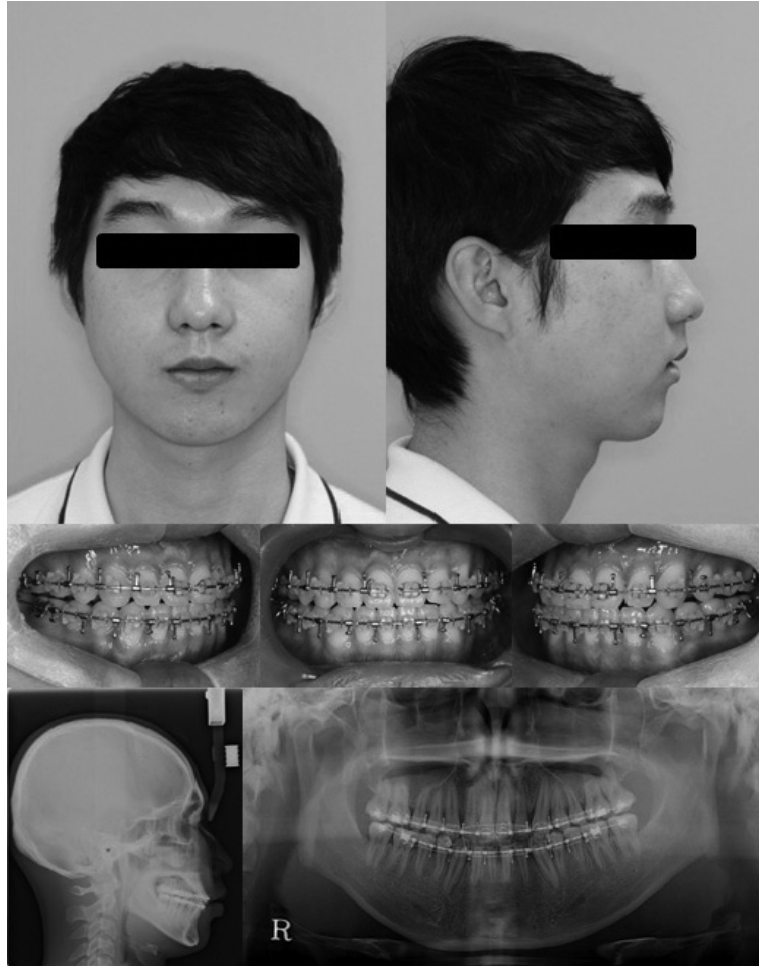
A 23-year-old male with mandibular prognathism and asymmetry before operation. Facial photographs, intraoral photographs, lateral cephalometric radiograph and panoramic radiograph.
